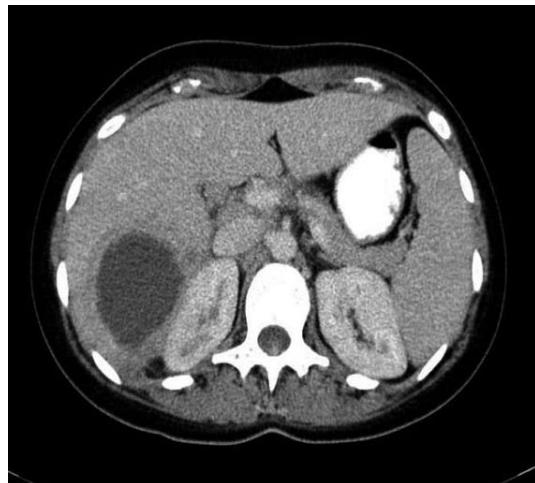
Abdominal CT with visible large liver abscess in the right lobe
